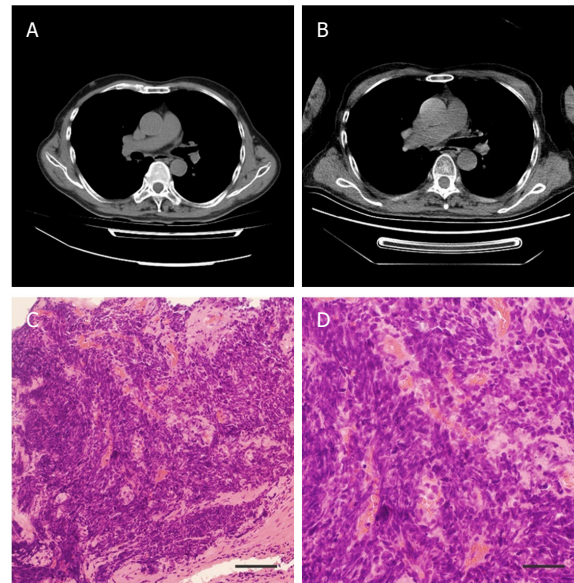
Chest CT scans and pathological result. A: only a right lower lobe inflammatory focus can be found. The chest CT scan was performed at the same time the eight cancer-driven mutations were detected (May 2017); B: the enlarged lymph nodes under the aortic arch can be seen, and a shadow of soft tissue around the aortic arch of the left lower lobe probably reflects a malignant lesion (January 2018); C, D: morphological results reflect the possibility of small cell lung cancer. Scale bar: 400 μ m (C); and 200 μ m (D)
